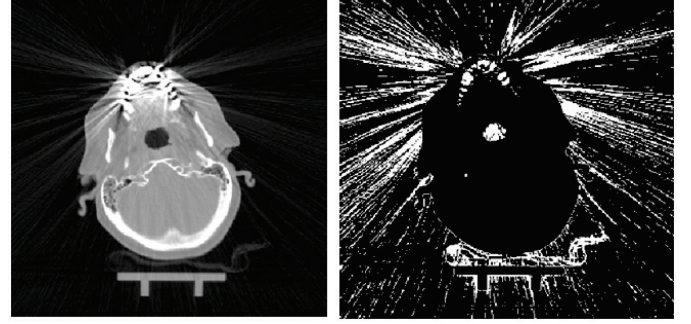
Axial view of a patient showing artifacts in the CT (left) and corresponding threshold mask (right)
